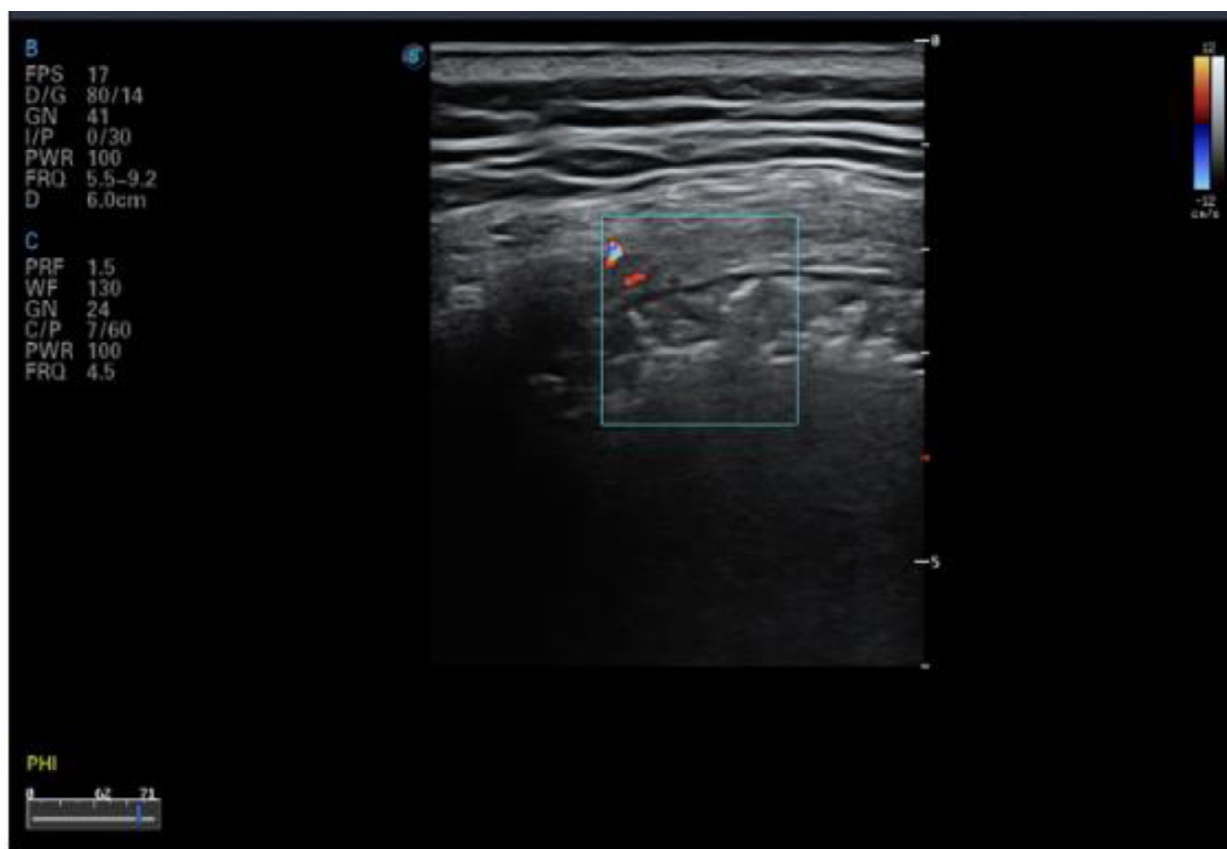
Color Doppler ultrasound image for confirmed COVID-19 case showing no blood flow signal in the peri-pulmonary consolidation of the left posterior upper area, a significantly different finding from that of common inflammatory bacterial pneumonia. Reprinted with permission from [Huang et al. \(2020\)](#).
